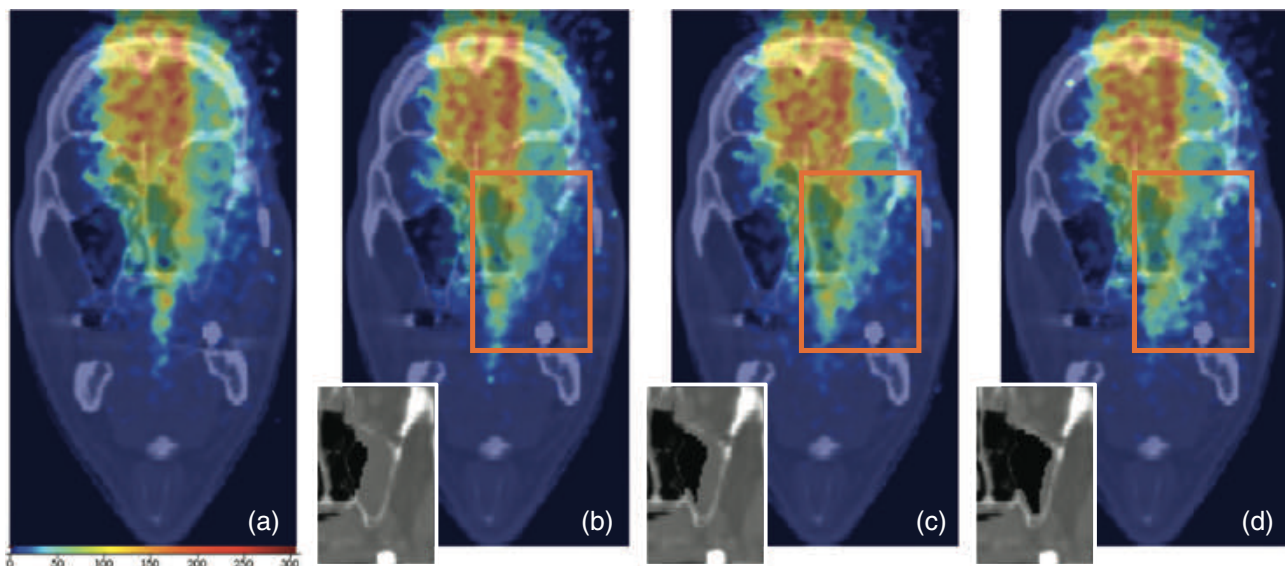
Evolution of the PET signal with the gradual emptying of the sinonasal cavity, overlaid on the planning CT, for cavity tissue volume reductions of 0 mL (a), 3.8 mL (b), 7.3 mL (c), and 13.1 mL (d). The small insets on the left bottom in (b), (c), and (d) represent the real underlying situation in the artificially modified CT
